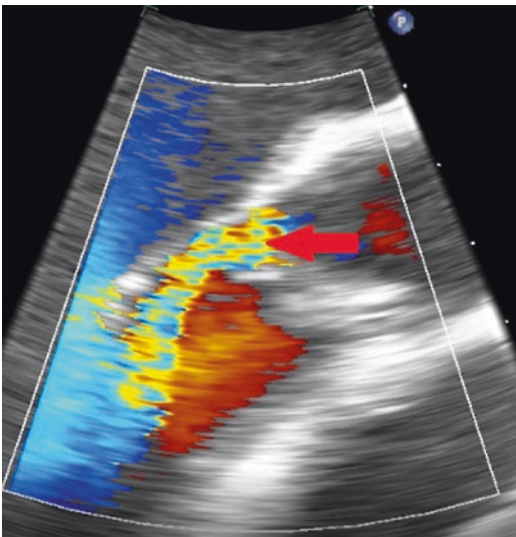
Destruction of the aortic valve leads to severe eccentric insufficiency (red arrow) seen on echocardiography
